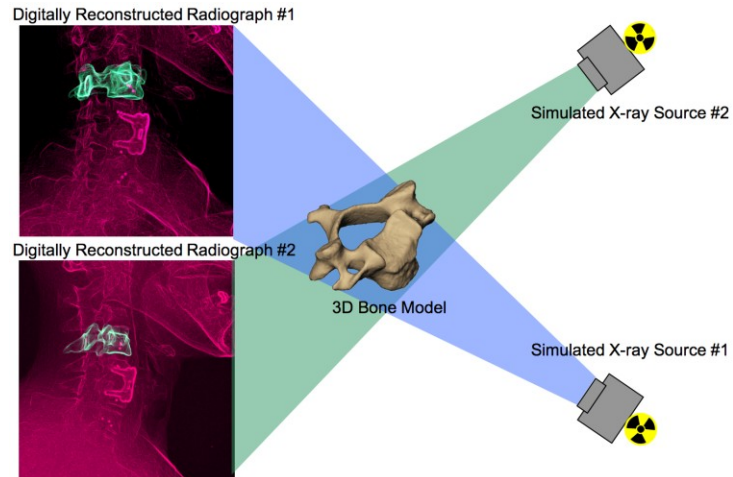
Virtual X-Ray system for model-based tracking.
